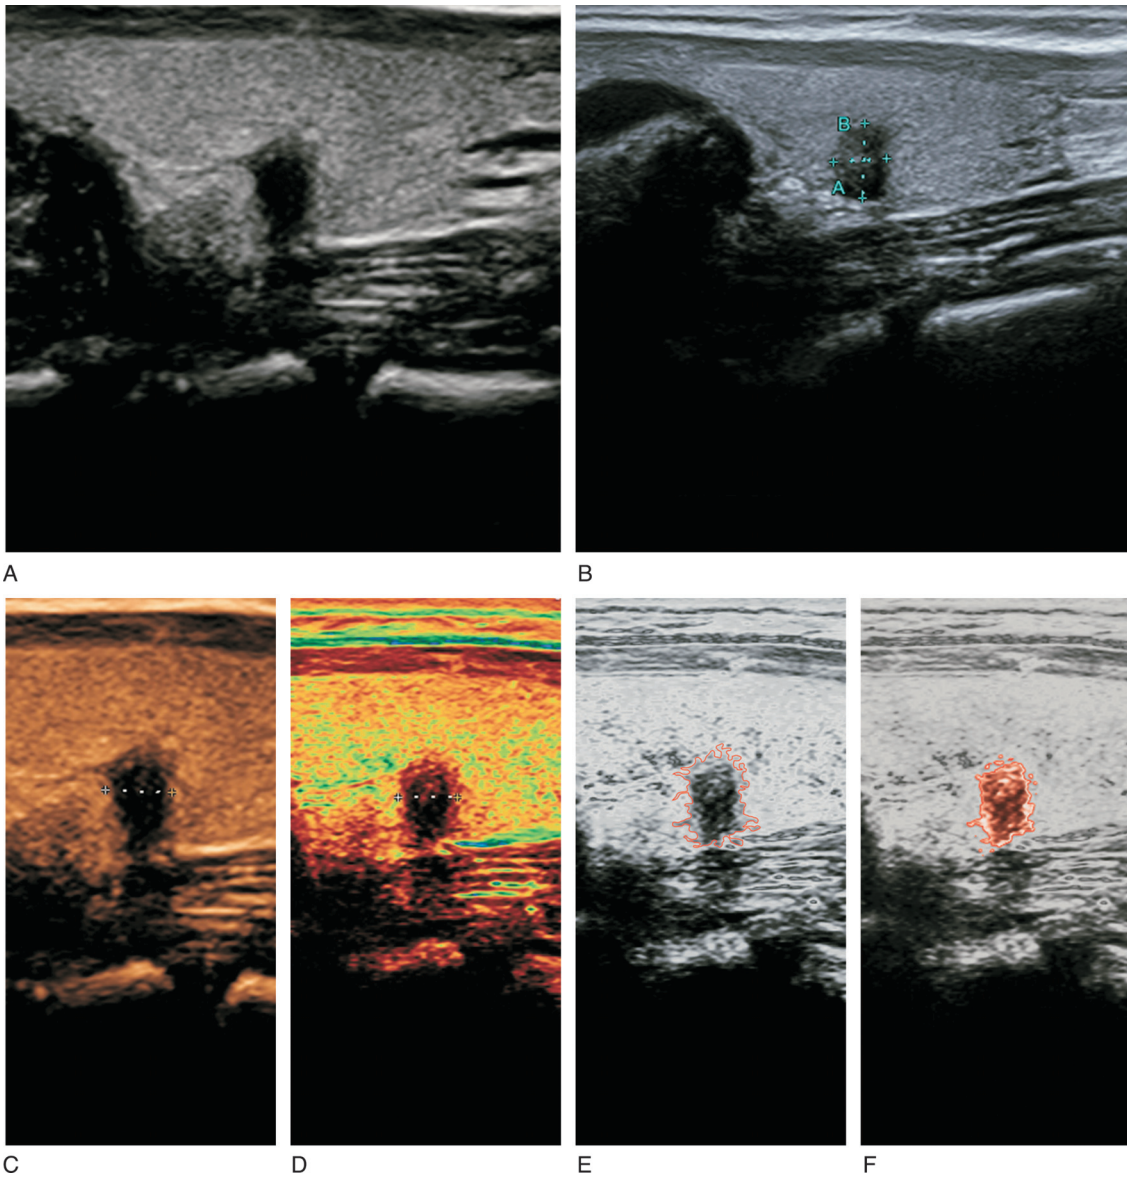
Black Ink Sonographic Pattern in 41-year-old Caucasian woman patient
